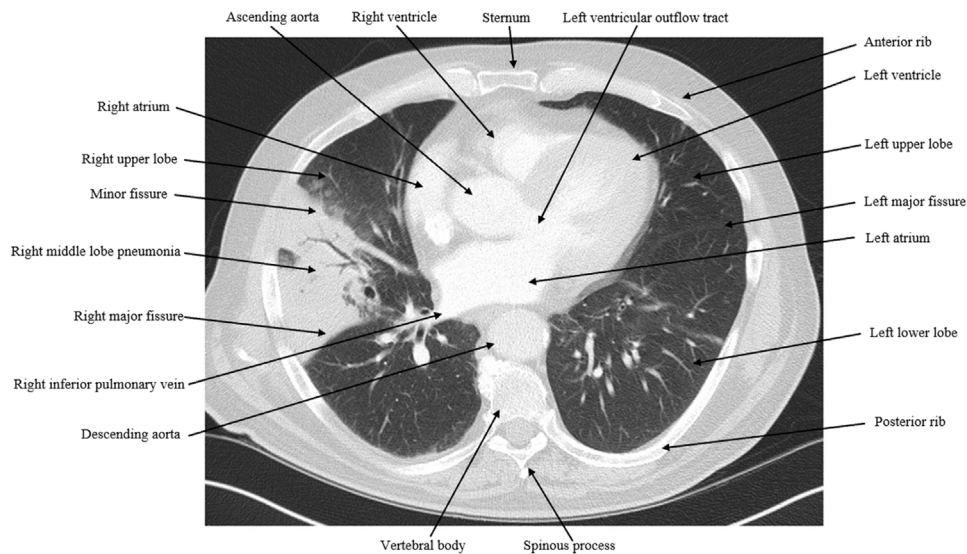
Labeled computed tomography scan (axial) showing lobar pneumonia of the right middle lobe.
